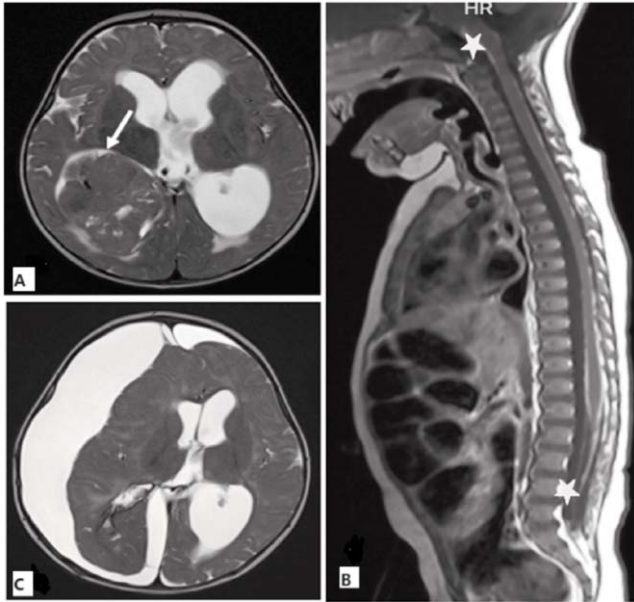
(Patient 2): Gadolinium enhanced MRI of the brain T2-weighted axial images (A, C); (A) an isointense to hyperintense and homogeneously enhancing mass lesion (white arrow) in the right lateral ventricle measuring approximately 45x63x69mm with marked dilation of all ventricles representing hydrocephalus; (B) T1 spinal sagittal image showing plaque-like patchy icing sugar pattern of post-contrast enhancement along the spinal cord and medulla oblongata (stars) consistent with metastatic disease and (C) interval resection of the previously seen lesion seen with a small area of residual abnormal signal intensity and corresponding enhancement within the surgical bed in the occipital horn of the right lateral ventricle likely representing residual disease.
